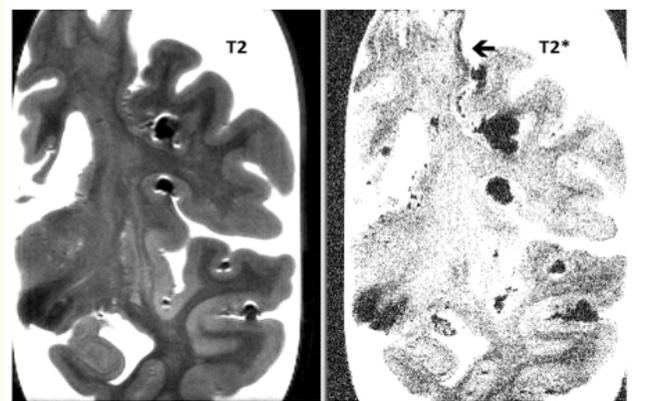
Spin-Echo T2 (A) and T2* (B) magnetic resonance imaging of a parietal coronal section of a cerebral hemisphere in a brain with progressive supranuclear palsy associated to cerebral amyloid angiopathy. Mild diffuse hyper-intensity of the corona radiata is observed on the T2 sequence and focal cortical superficial siderosis on the T2* one (arrow).
